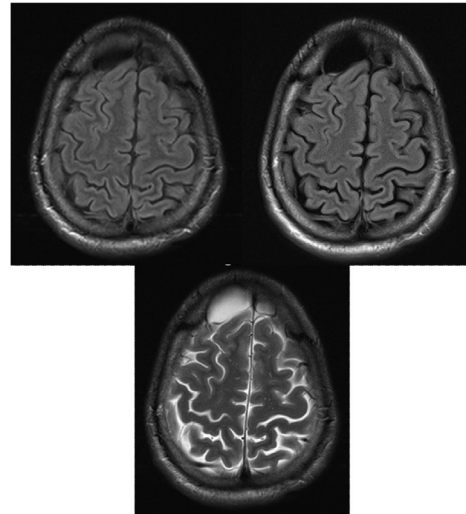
Axial T2 fluid attenuated inversion recovery (FLAIR) (upper left), Axial T2 FLAIR BLADE (upper right) and T2 turbo spin echo (TSE) (lower) images of the brain. It is very important to depict the exact limits of an arachnoid cyst in order to be able to determine any possible enlargement of the cyst. Here, it is shown that chemical shift artifacts are reduced in T2 FLAIR BLADE image and better cerebrospinal fluid (CSF) nulling is achieved, which results in a more accurate depiction of the pathology. BLADE images provide the possibility for performing more precise measurements compared to those obtained from T2 TSE images.
